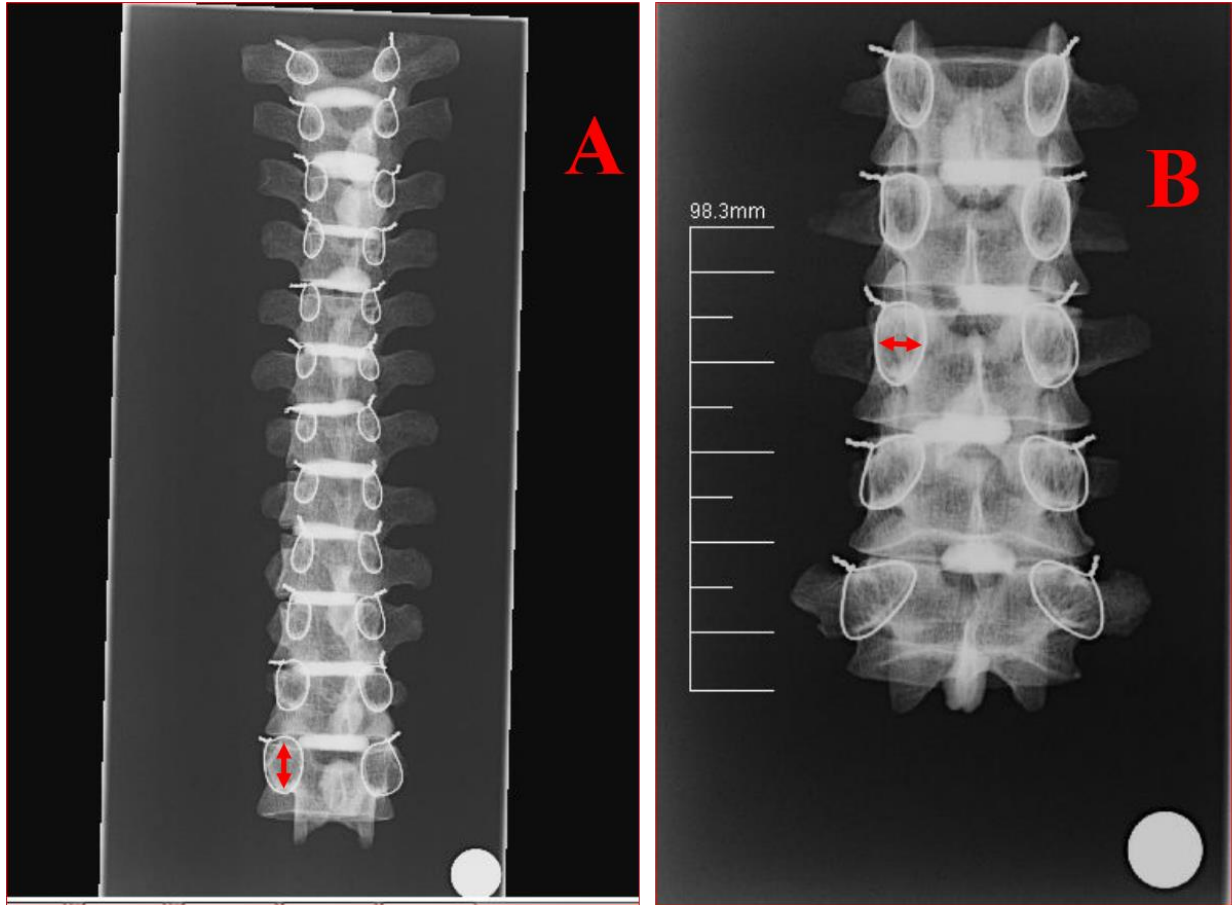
Anterior radiographs of thoracic (A) and lumbar (B) vertebrae showing measurements of transverse inner cortical diameter (red arrow in B) and vertical inner cortical diameter (red arrow in A)
